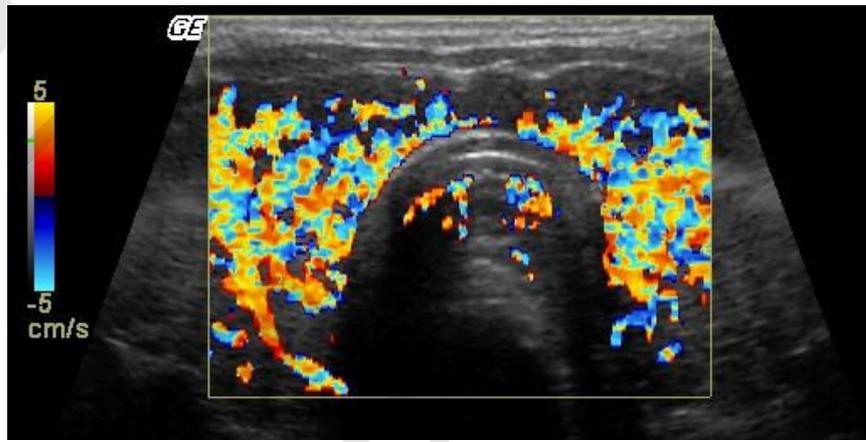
Ultrasound picture of Graves' disease showing marked hyper vascularity (thyroid inferno sign)
